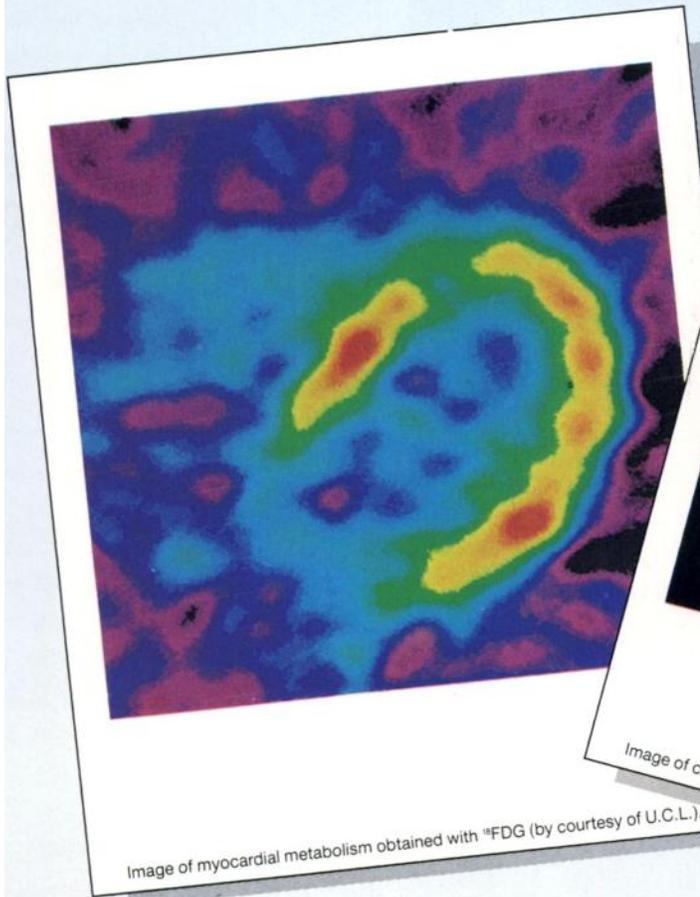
Image of myocardial metabolism obtained with ^{18}F FDG (by courtesy of U.C.L.).
